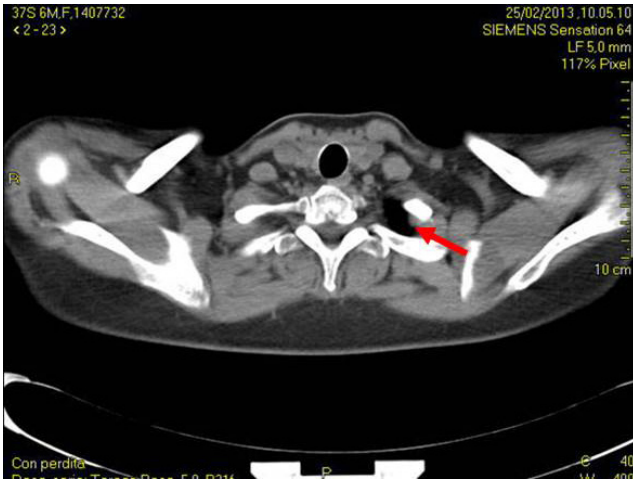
CT scan showing reduced air in the subcutaneous tissues of the base of the neck after 3 weeks
